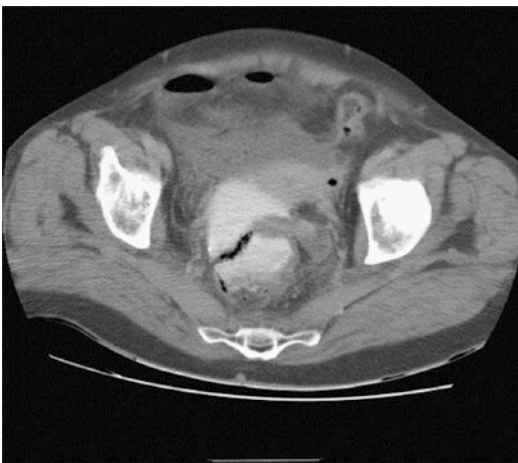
CT scan to detect leak
